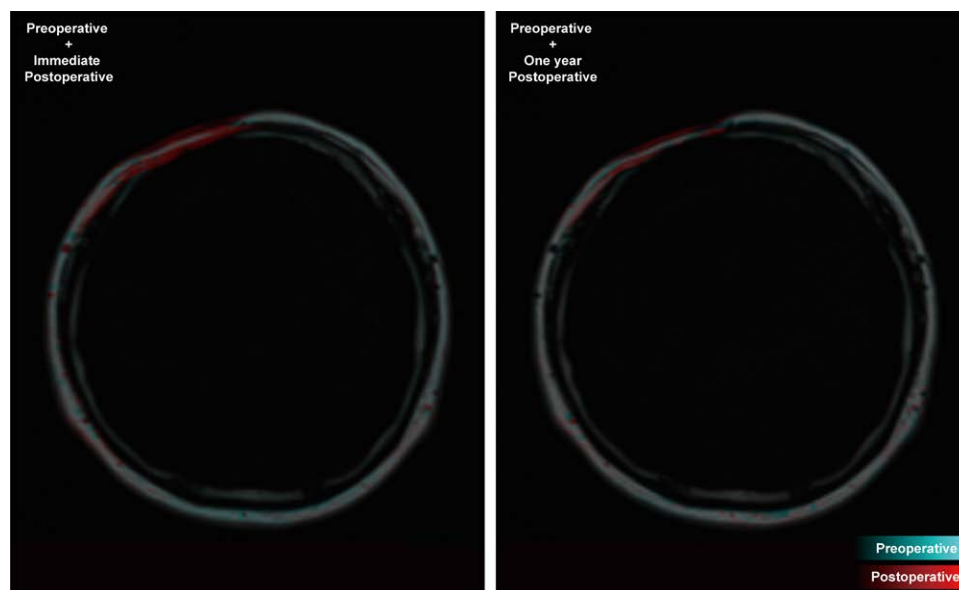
Fused MRI scans (patient 14, upper face) show that forehead injections were supplemented primarily underneath the frontalis (or aponeurosis), with small amounts subcutaneously.
